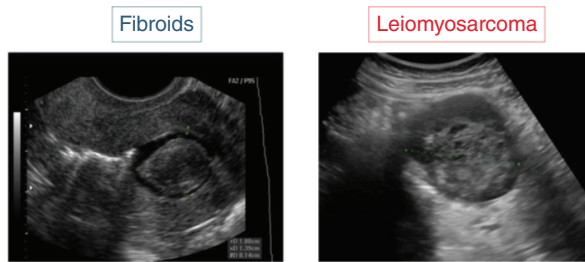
Ultrasound images of uterine fibroids and leiomyosarcoma.
